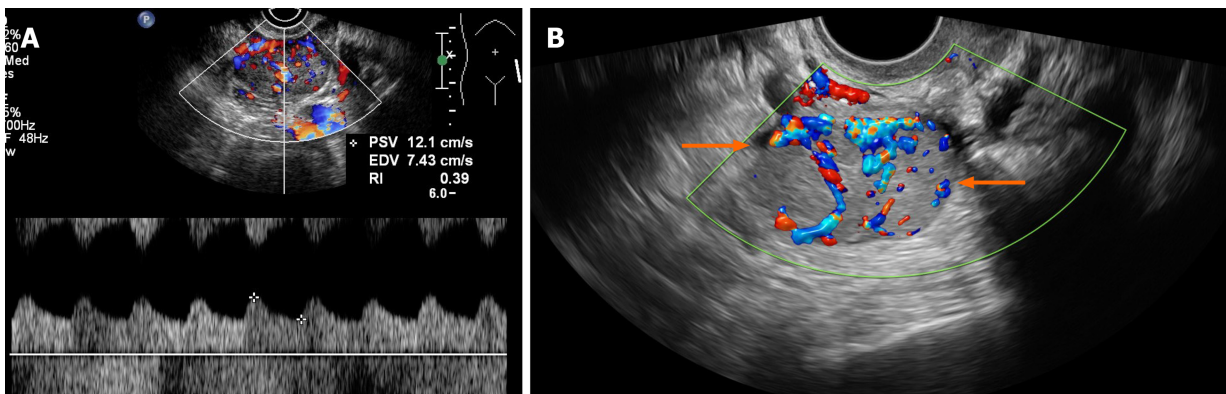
Color Doppler flow imaging. A: Color Doppler flow imaging (CDFI) showed an abundant blood supply with a resistance index of 0.39 (case 2); B: CDFI showed an abundant blood supply in the mass (case 3).
